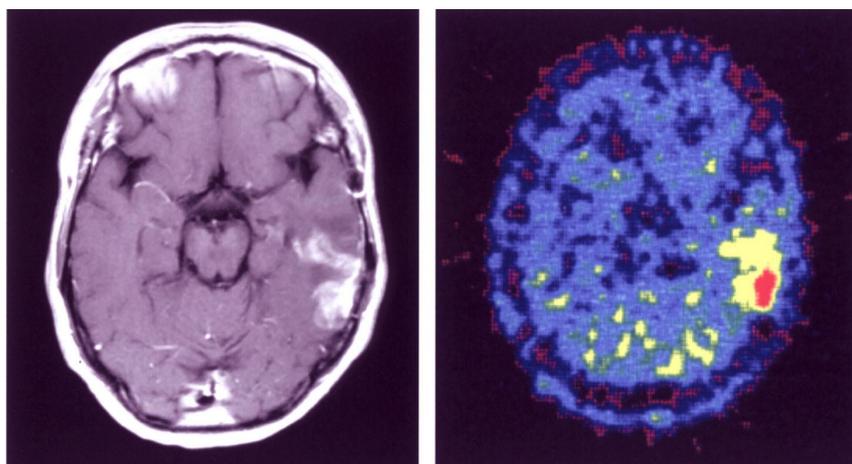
Case #5: radiation necrosis. *Left*: MRI reveals an enhanced lesion in the left temporal lobe at six months after SRS. *Right*: Met-PET reveals increased uptake in the lesion and TN volume is high (2.06).
